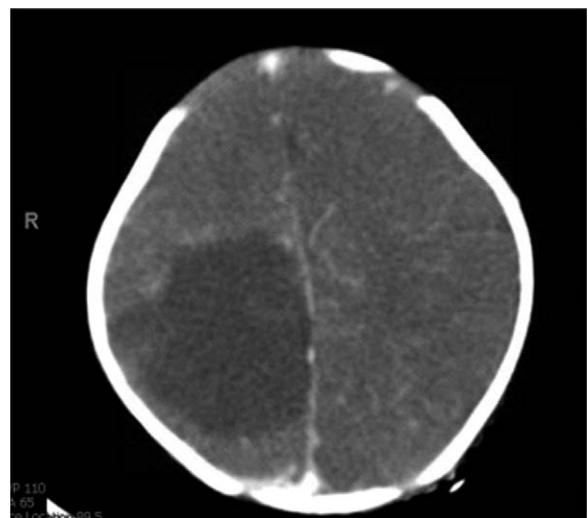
Head CT shows a rim-enhancing low-density lesion in the right parietal lobe without significant surrounding edema.
